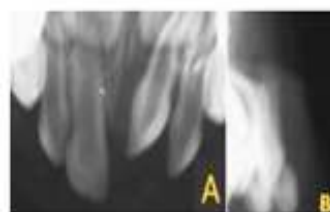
A. The intruded tooth appears shorter than its contralateral in the periapical X-ray. B. In the lateral X-ray, the apex of the intruded tooth is displaced through the labial bone plate.⁵
